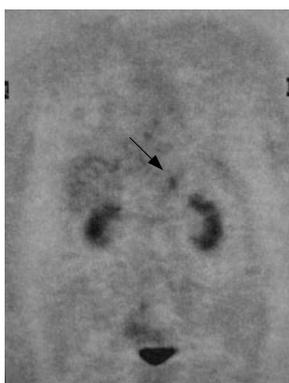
FDG-PET/CT. FDG uptake in the left adrenal gland (black arrow). The maximum standardized uptake value was 2.8, and no FDG uptake was seen anywhere else.
